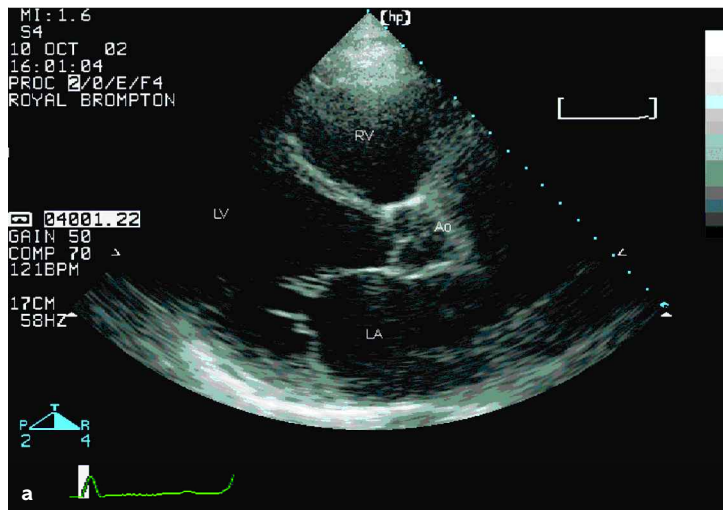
(a) Parasternal long-axis 2D-echocardiogram demonstrating a dilated left ventricle in diastole in a patient with heart failure; (b) M-Mode echocardiogram of the same ventricle demonstrating extremely poor basal left ventricular contraction (red bars = cm markers).
